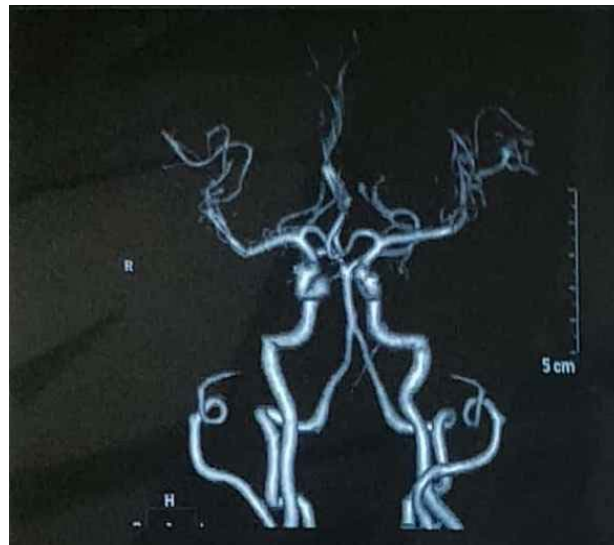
CT Angiogram showing an aneurysm at the distal branch of Left MCA
